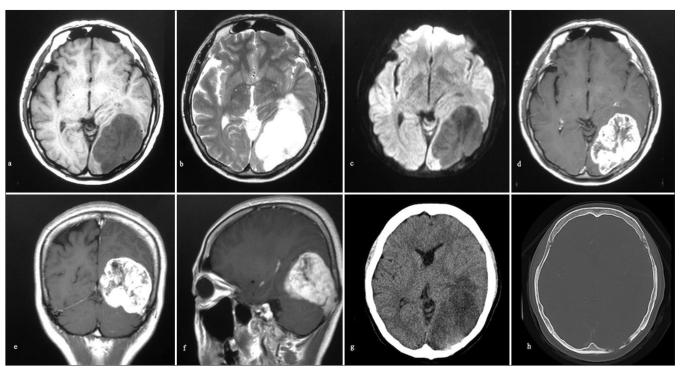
(a-c) Preoperative magnetic resonance imaging (MRI) T1-weighted imaging, T2-weighted imaging, and diffusion-weighted images showed a well-defined round tumor in the left occipital lesion, (d-f) Gadolinium-weighted images of the head MRI showed an irregularly enhancing tumor. (g and h) Preoperative computed tomography of the head showed osteolytic changes in the cranium and no intratumoral calcification.
